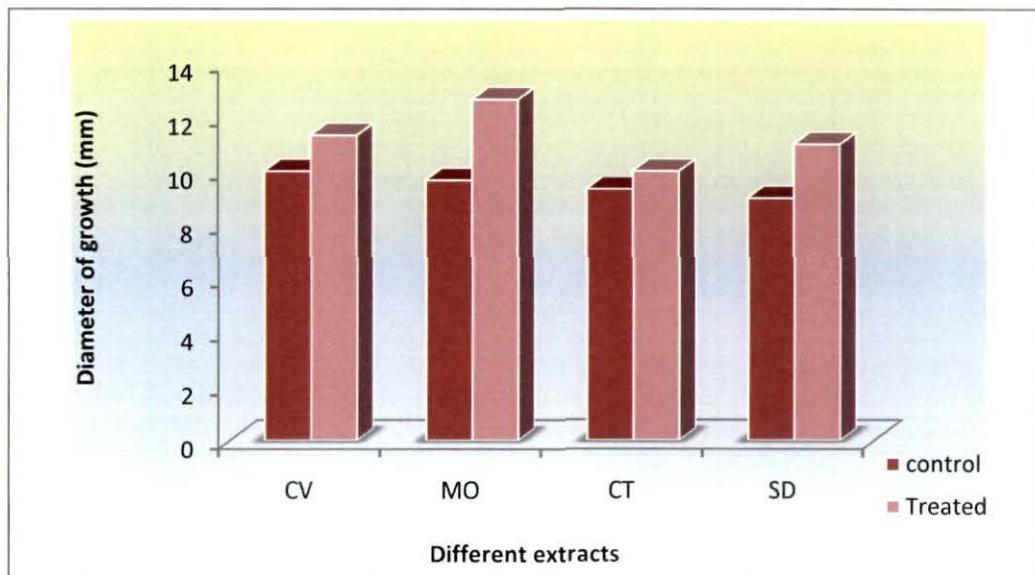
Effect of different extracts on mycelial growth by Agar cup bioassay of *Poria hypobrunnea*. (CV= *Clerodendrum viscosum*, MO= *Moringa oleifera*, CT= *Cinnamomum tamala*, SD= *Scoparia dulcis*.
